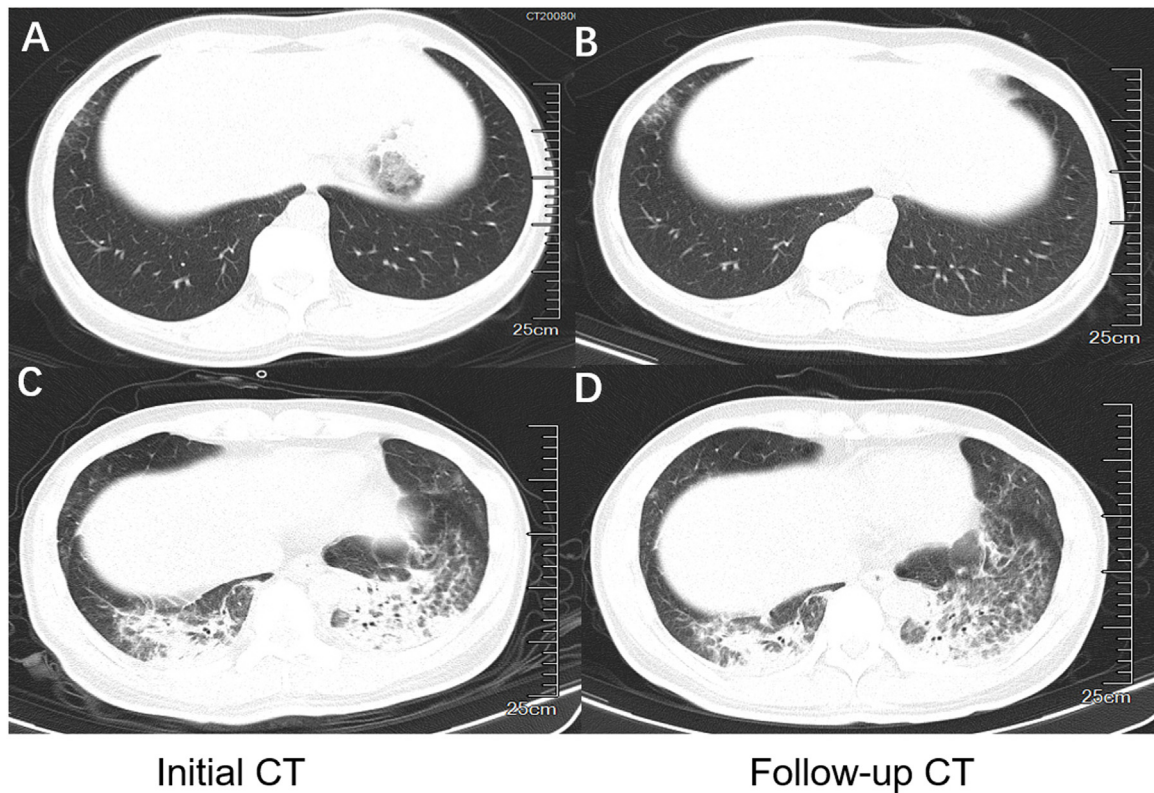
Dynamic changes of CT images in patients with co-infection of SARS-CoV-2 and HIV. (A and B) 50-year-old female, non-severe type. Follow-up CT scan showed increased density of the ground-glass opacity in the right lower lobe 21 days after initial scan. (C and D) 38-year-old male, severe type. Follow-up CT scan showed partial resorption of consolidation in the left lower lobe 8 days after initial scan.
